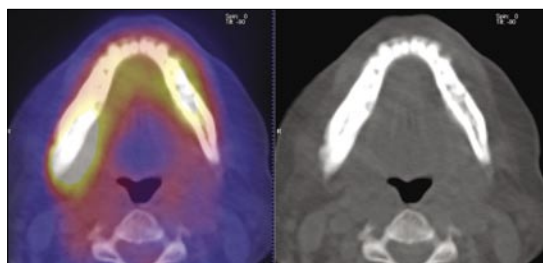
PET/SPECT of a 54-year-old female with a history of breast cancer with metastases to bone and lung, and multiple chemotherapies. PET/CT images demonstrated intense hypermetabolic activity in the right mandible greater than the contralateral side. These findings are consistent with Zometa-associated biopsy-proven osteonecrosis (courtesy of Dr. Peter Conti, PET Imaging Science Center, USC University Hospital).
